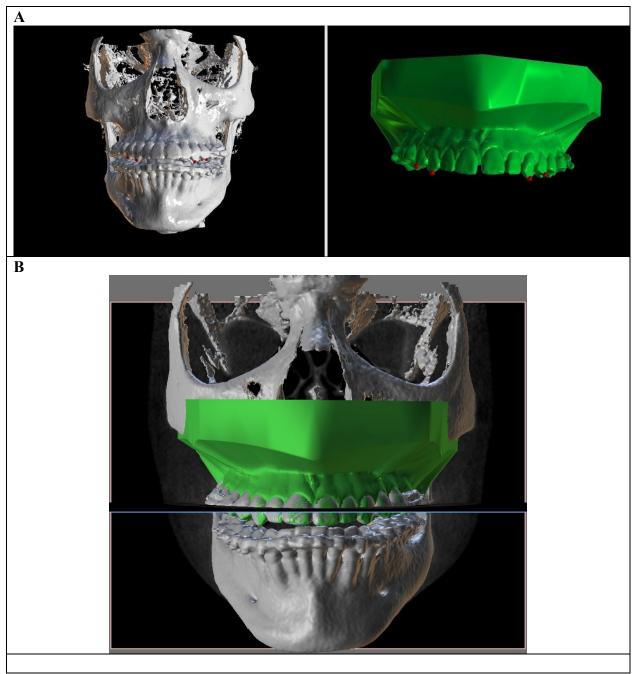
Super imposition of Intraoral scan data on CBCT.
